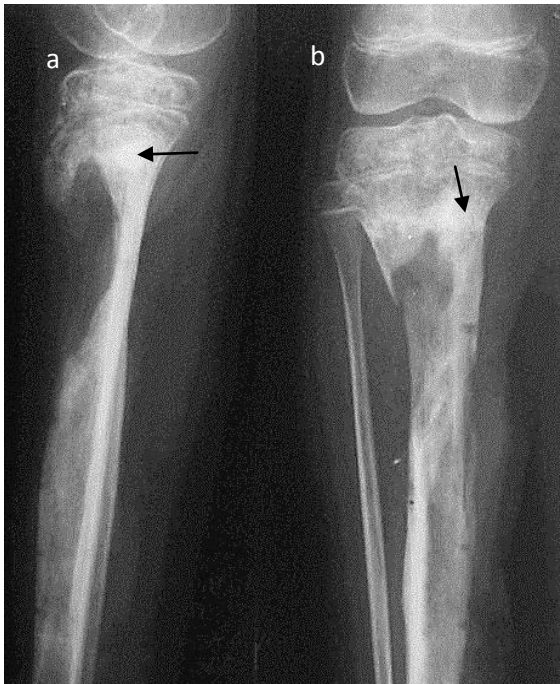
X-ray film of the left shin in direct and lateral projections. Extensive zones of destruction in proximal metaphysis and in diaphysis of the tibia. Evident osteosclerosis is around the centres of destruction (arrows). Osteoporosis of the articular ends of bones of a knee joint. Chronic osteomyelitis of the left tibia
